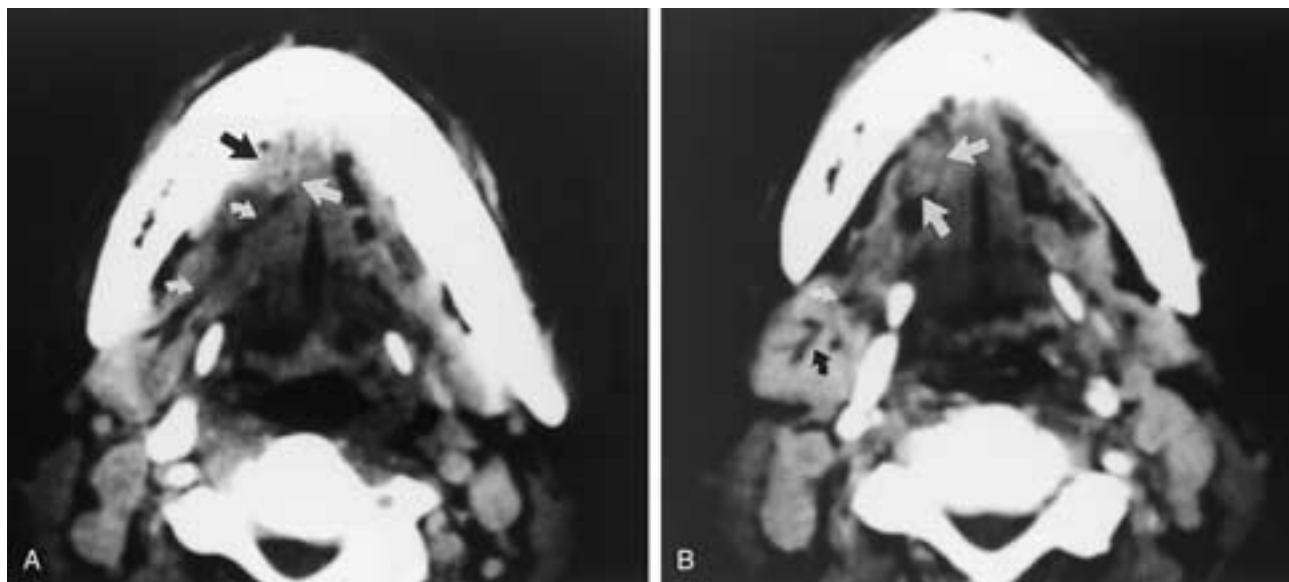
Right squamous cell carcinoma of the floor of the mouth with obstruction of the submandibular gland duct. A and B, Axial contrast-enhanced CT images demonstrate a tumor in the right floor of the mouth (*straight arrows*), which is best identified by noting the asymmetry of the sublingual space fat between the two sides. The tumor has obstructed the submandibular duct distally, and main duct dilatation (*curved arrows in A*) as well as dilated intraglandular ducts (*curved arrows in B*) are noted.
